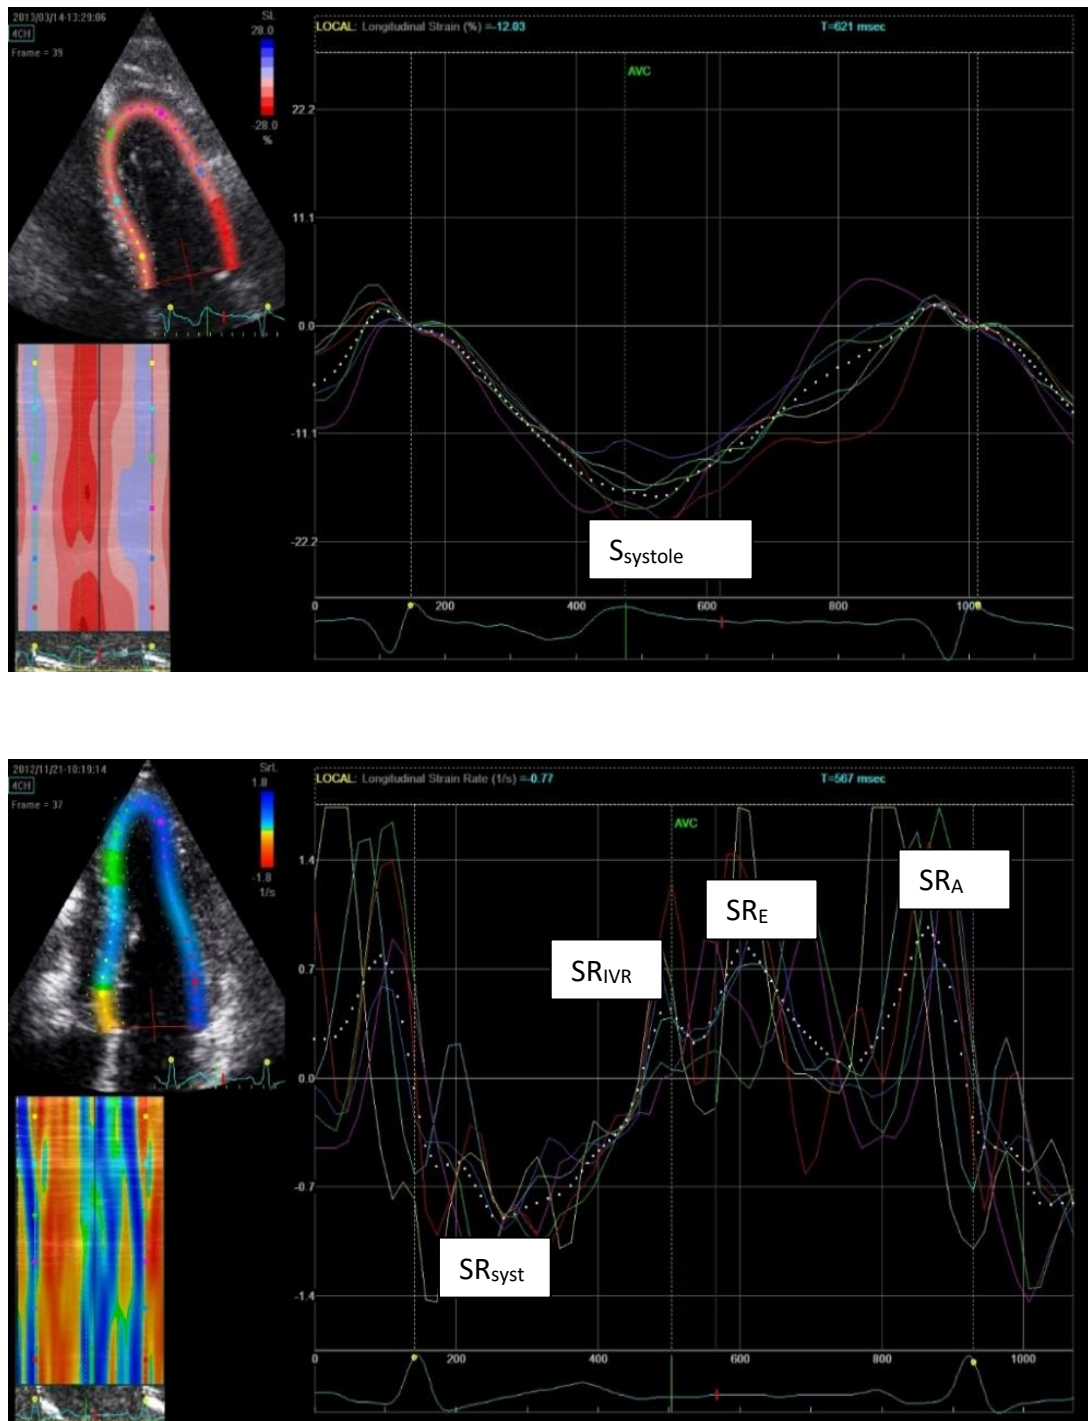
2DSTE trace from apical 4-chamber view of LV: longitudinal strain (top panel) and strain rate (bottom panel) graphs.
